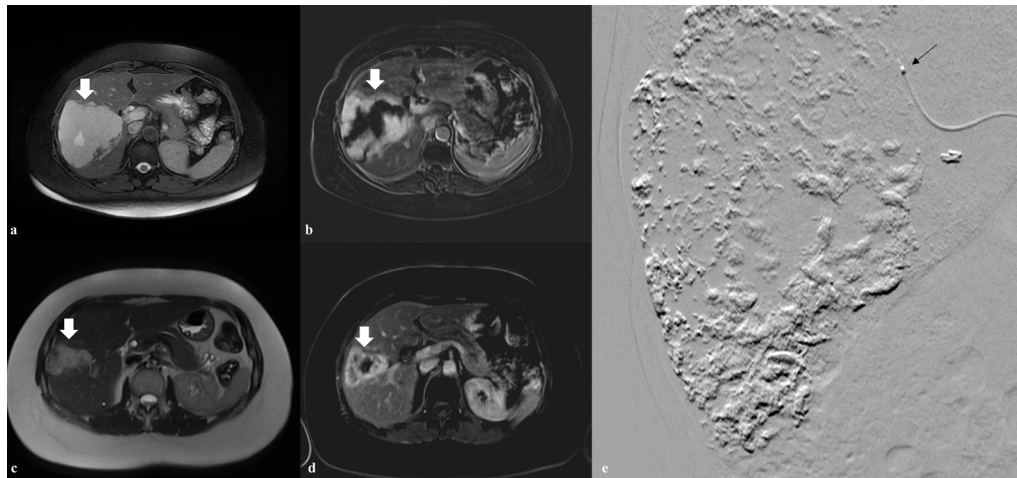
A patient presenting with early satiety and dyspeptic complaints was found to have a lesion in the left lobe of the liver, indicated by the arrow. After the procedure, the patient experienced marked symptomatic improvement. A) Preoperative axial T2-weighted image. B) Preoperative axial contrast-enhanced T1-weighted image. C) Postoperative axial T2-weighted image. D) Postoperative axial contrast-enhanced T1-weighted image. C, D) Postoperative images demonstrate a significant reduction in lesion size. E) Angiographic image showing complete embolization of the lesion through a super-selective microcatheter approach (thin white arrow), using a bleomycin-lipiodol mixture delivered into the feeding artery
